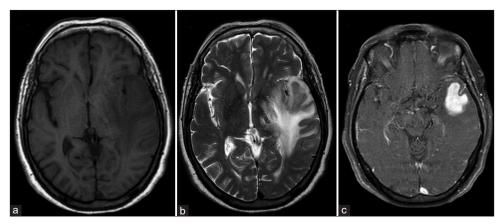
(a-c) Admission magnetic resonance imaging: large expansive intraparenchymal lesion in the left superior temporal gyrus with vasogenic edema, mass effect, and midline shift. Mild vascular engorgement of M2/M3 branches of the left middle cerebral artery.
